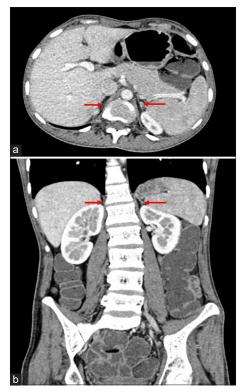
Contrast-enhanced computed tomography of abdomen showing bilateral diffusely atrophic adrenal glands (red arrows) in (a) axial and (b) coronal sections. Maximum width of body, medial limb, lateral limb of right and left adrenal gland are 2.1 mm, 1.4 mm, 1.3 mm and 1.7 mm, 2.2 mm, 1.5 mm, respectively.
